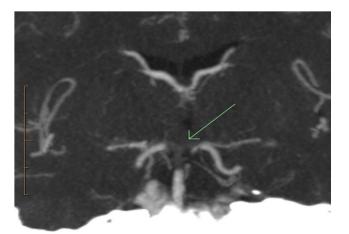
CT angiography - Basilar occlusion
